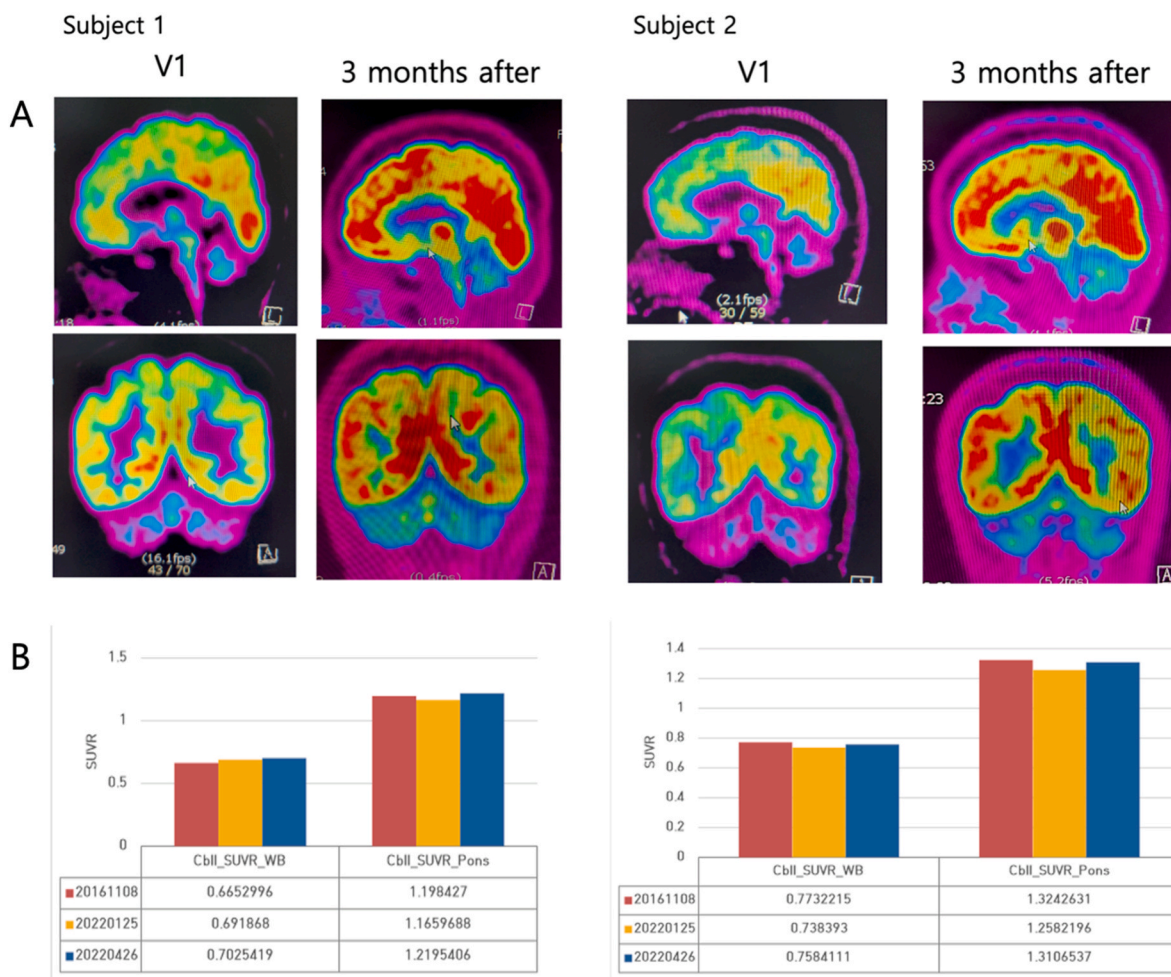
Changes in the (A) original FDG PET/CT and (B) FDG PET/CT SUVR quantification before and after taking KRG in two subjects. Coincidentally, both participants had taken FDG PET/CT scans in 2016, which were also compared (indicated in red). Each graph on the left and right shows the cerebellar glucose uptake ratio to the whole brain (WB) and Pons, respectively. The pons, with its stable and uniform tracer uptake, and the whole brain are often used as reference regions to compare changes in cerebellar metabolic activity. FDG PET/CT; fluorodeoxyglucose positron emission tomography-computed tomography, SUVR; Standardized Uptake Value Ratio, KRG; Korean Red Ginseng.
